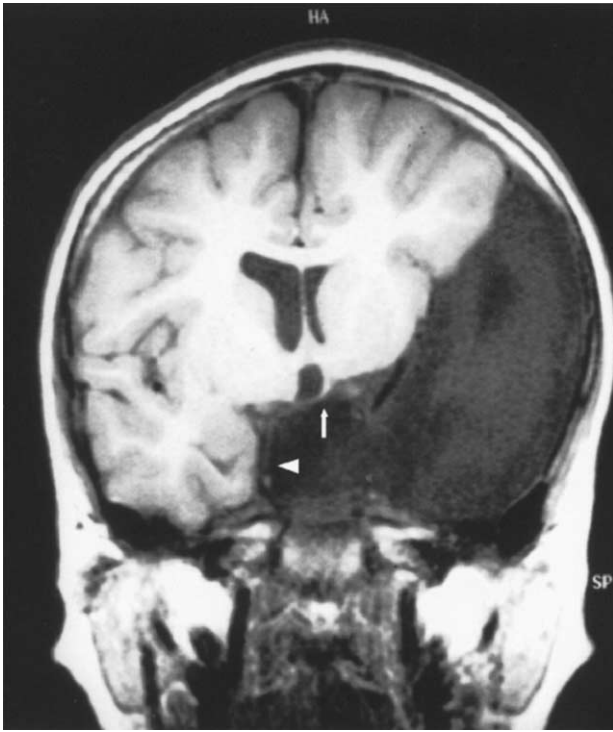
Coronal T_1 -weighted magnetic resonance image without contrast medium (TR = 650 ms, TE = 14 ms) revealed a large arachnoid cyst, which extended to the suprasellar region with distorted left hypothalamus (arrow) and pituitary stalk (arrowhead).
